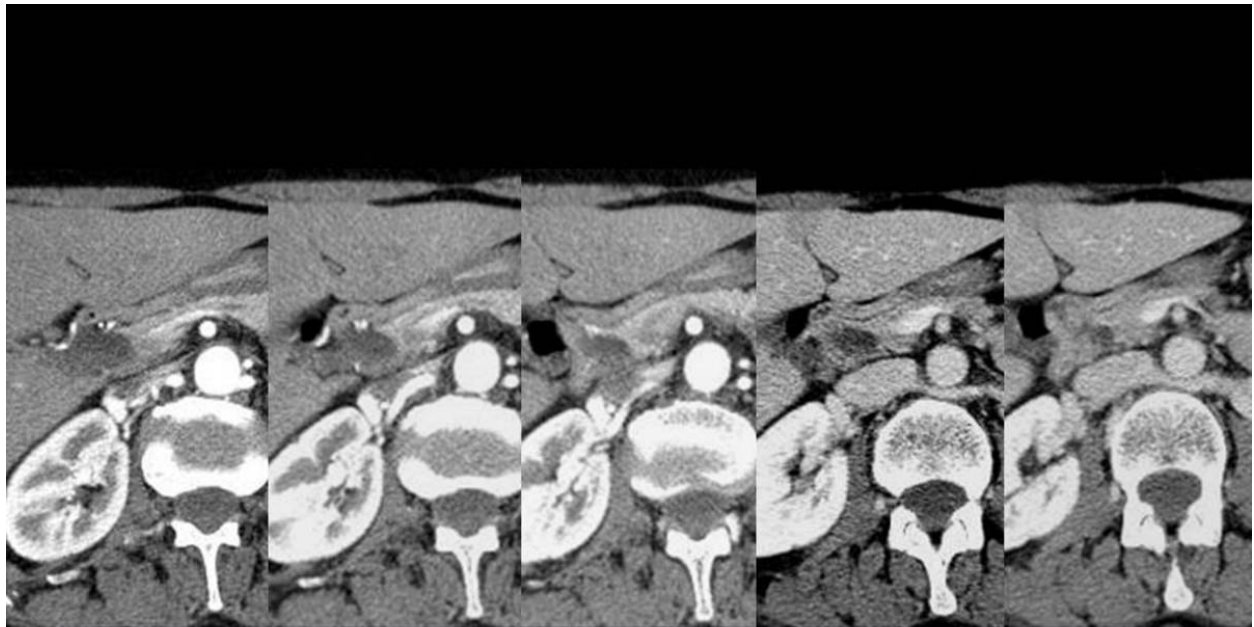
Choledochal cyst type I. Enhanced CT images show a fusiform dilatation of the main bile duct in its distal third. The dynamic study helps to differentiate these lesions.
